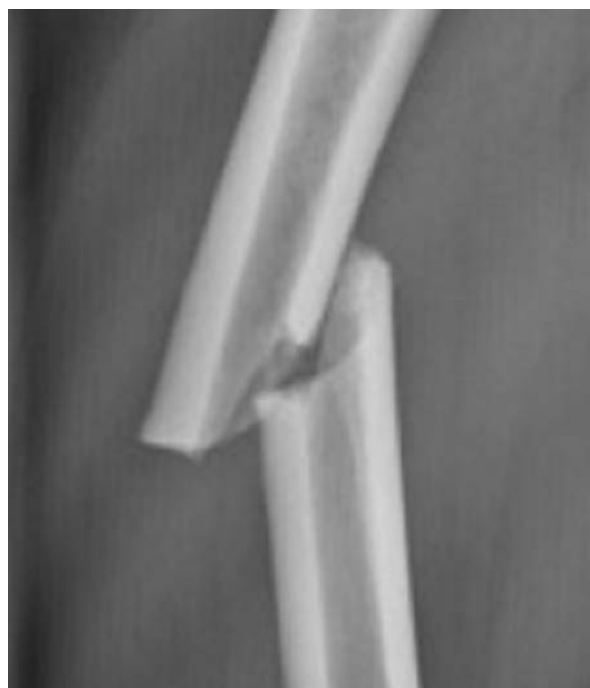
X-ray pattern of the fracture: A horizontal fracture line and a medial cortical spike. Notice the thickened lateral cortex.
